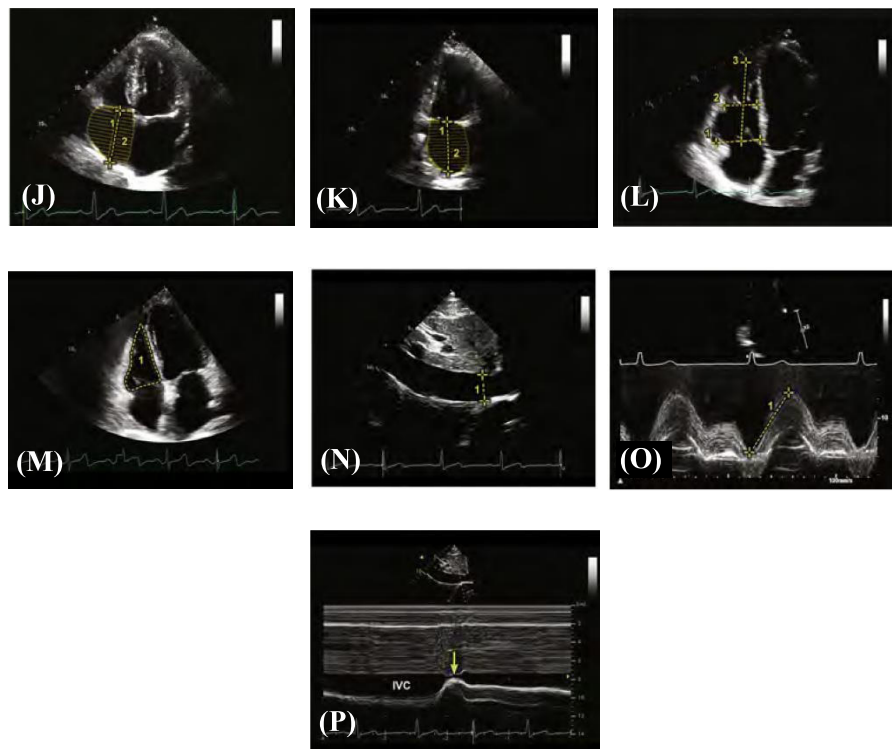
Echocardiographic Measurements: (J) A4C view, measurements made: RA length and RA area; (K) A2C view, measurements made: RA length and RA area; (L) A4C view (RV Focused), measurements made: RV base diameter, RV mid-cavity diameter, and RV length; (M) A4C view (RV Focused), measurement made: RV area; (N) SIVC view, measurement made: IVC diameter; (O) A4C view (RV Focused), M-mode measurement made: TAPSE; (P) SIVC view, demonstrating IVC reactivity (Arrow demonstrates patient sniffing maneuver or IVC collapsibility). Abbreviations: Aortic Valve (AoV); ascending aorta (Asc Ao); sinus of Valsalva (SoVAo) (Mitchell et al., 2019)
